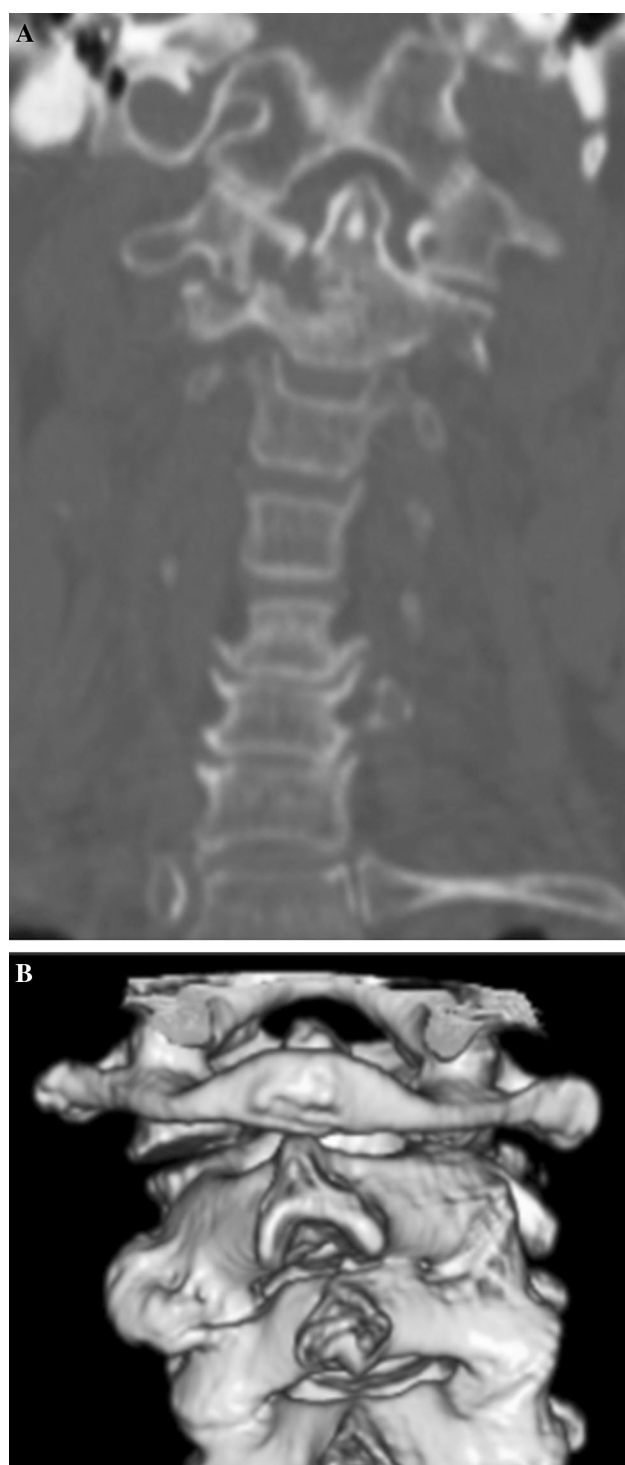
CT revealed pinching of the articular surfaces of the fractured atlas and axis. a Coronal section. b Three-dimensional
